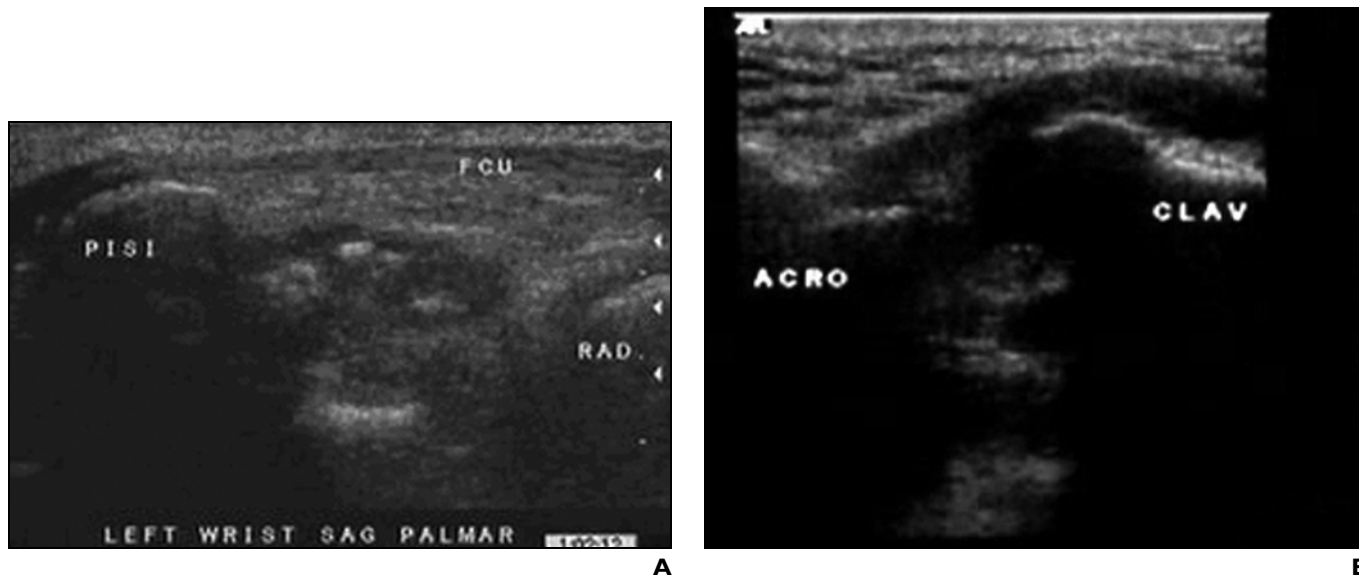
Joint disorders. A, Sagittal sonogram of palmar and ulnar aspect of wrist shows multiple small round hyperechoic bodies in distended pisiform-triquetral joint recess. With motion and compression (for video, see supplemental Figure S12A), mobility of these bodies is well shown (sagittal, followed by transverse scan of same region). PISI = pisiform bone, FCU = flexor carpi ulnaris tendon, RAD = radius. B, Coronal sonogram of right acromioclavicular joint shows increased mobility during shoulder motion. For video, see supplemental Figure S12B. ACRO = acromion, CLAV = clavicle.
